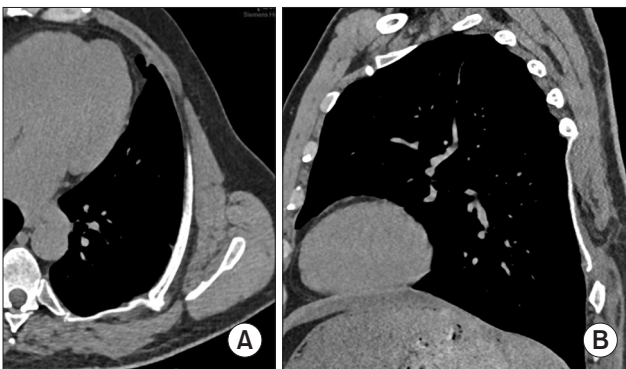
(A, B) Computed tomography images of chest wall reconstruction 5 months after surgery.
